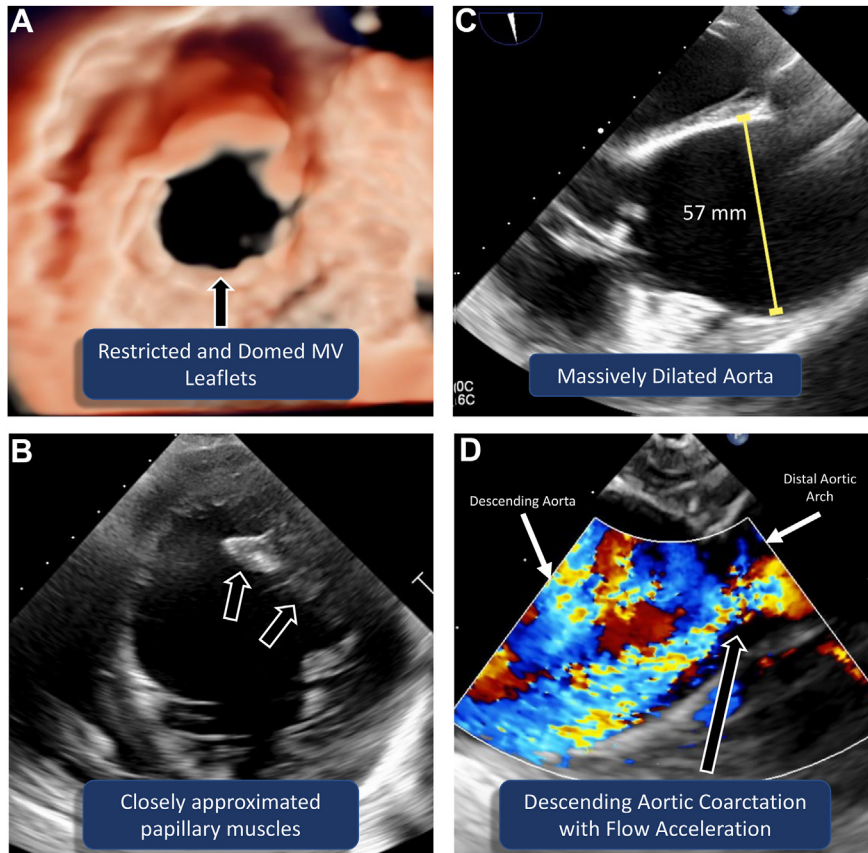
(A) Three-dimensional TEE, photorealistic volume-rendered image, diastolic phase from the LV perspective, demonstrates the dysmorphic MV with domed leaflets. (B) Two-dimensional TTE, transgastric short-axis mid-LV view, demonstrates the closely approximated papillary muscles with parachute-like morphology. (C) Two-dimensional TTE, midesophageal diastolic long-axis view, demonstrates the severe ascending aortic dilation. (D) Two-dimensional TTE with color-flow Doppler, long-axis view of the descending aorta in systole, demonstrates flow acceleration consistent with CoA.
